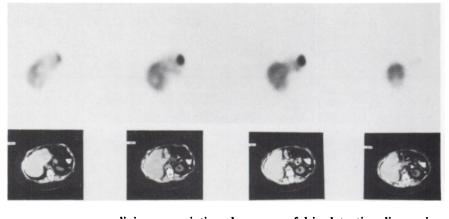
A 56-yr-old female (Patient 4/15) presented with a rising serum CEA. On CT (lower right), two lesions were seen in the superior right lobe and the caudate lobe of the liver. Only the superior right lobe liver lesion concentrated radioactivity selectively. The relevant CT slice is in the lower right. The caudate lobe liver lesion seen on CT was seen to be a hepatic cyst on intraoperative ultrasound and palpation. Representative 48-hr SPECT images (transverse, upper panel; coronal, middle panel; sagittal, lower panel) are shown. Reference planes are on the upper right.
